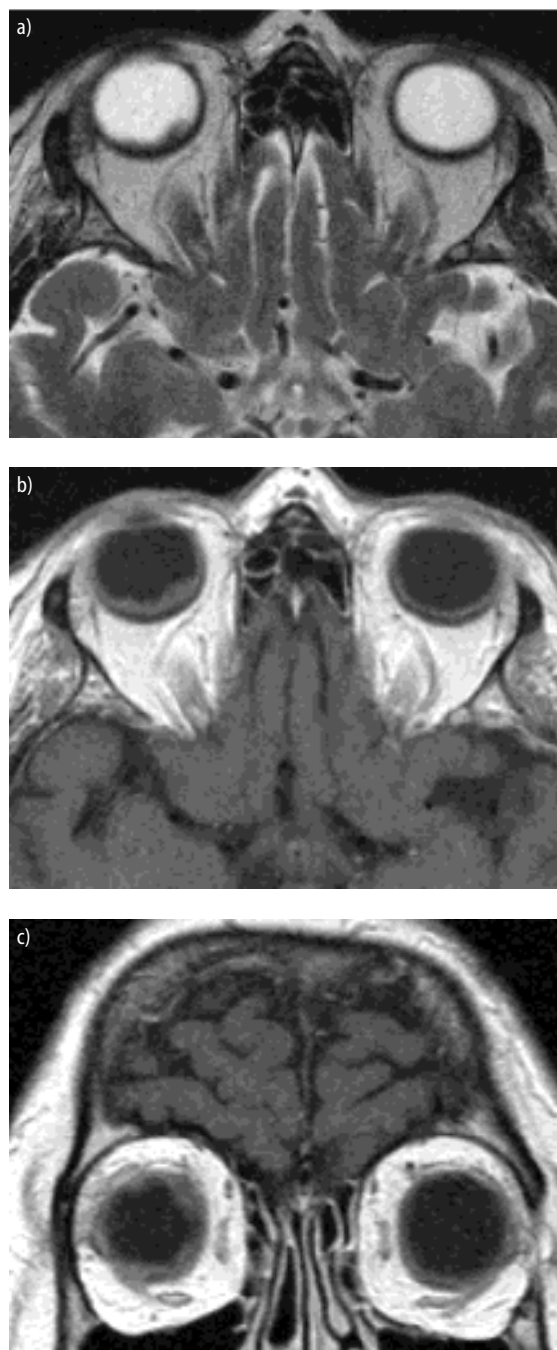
(a) T2-weighted thin section image of the orbit (slice thickness = 3mm). There is a hypointense lesion in the right eye adjacent to the posterior wall of the bulbus. (b) T1-weighted image (slice thickness = 3mm) of the orbit after injection of Gd-DTPA. The mass in the dorsal part of the eye shows enhancement. (c) T1-weighted sequence (slice thickness = 3mm) after contrast administration. The circular intraocular mass lesion is clearly visible.
